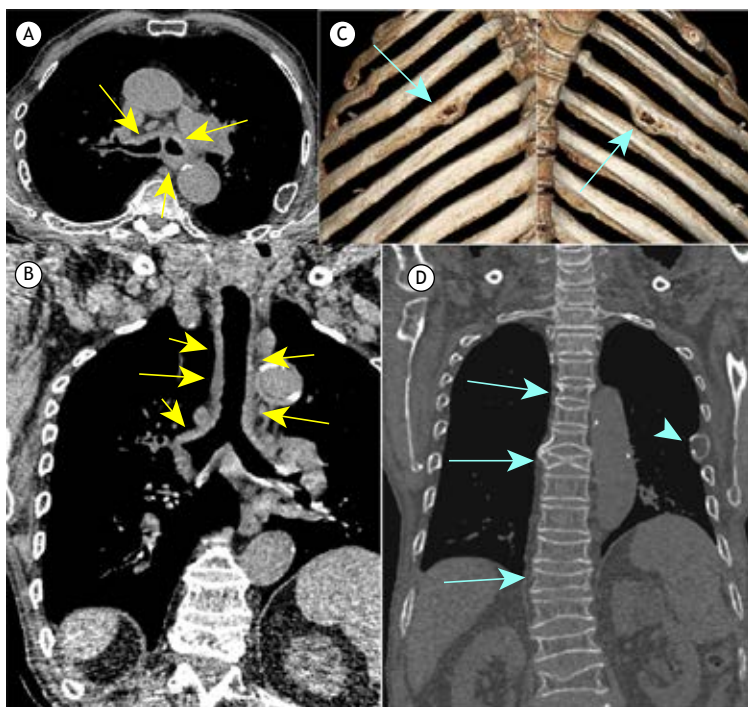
Axial CT of the chest (mediastinal window) at the level of the proximal segment of the bronchial bifurcation (in A) and a coronal reconstruction scan (in B) showing thickening of the tracheal wall and main bronchi (yellow arrows). In C, three-dimensional reconstruction of the chest wall demonstrating bilateral lytic lesions on the ribs (blue arrows). In D, coronal reconstruction showing partial collapse of multiple vertebral bodies (green arrows) and a lytic lesion on a left rib (arrowhead).
